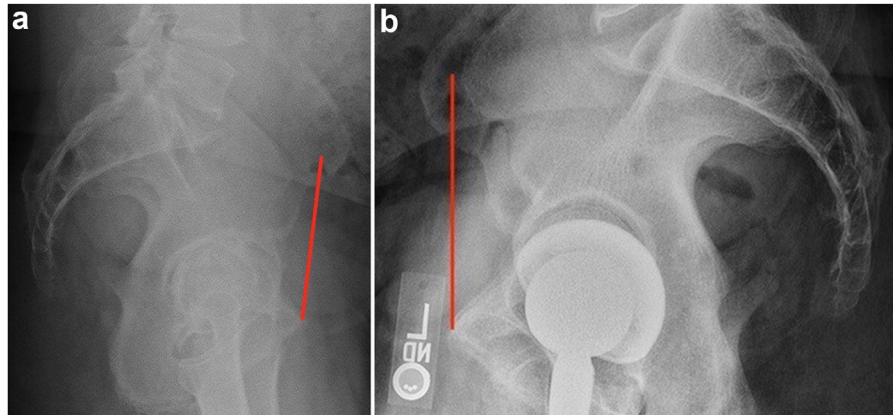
Lateral pelvic radiograph showing pelvic inclination prior to surgery (a) and 1 year after THA (b) (measured angle created between line on symphysis and anterior superior iliac spine [ASIS] vs vertical line): Pelvic inclination changed from 7 degrees anterior tilt to 2 degrees posterior tilt from preoperative to 1 year postoperative.
